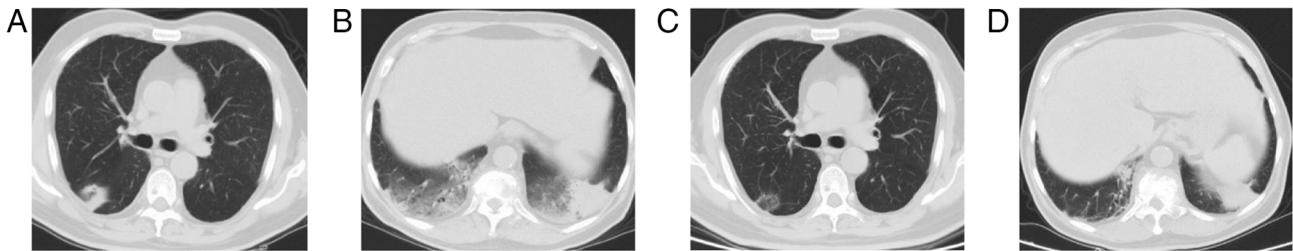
CT images of checkpoint inhibitor pneumonitis before and after corticosteroid therapy. (A) CT image at the level of the intermediate bronchus showing pneumonitis after three cycles of immunotherapy (October 2020). (B) CT image at the level of the bilateral lower lung showing pneumonitis after three cycles of immunotherapy (October 2020) (C) CT image at the level of the intermediate bronchus showing notable improvement of pneumonitis after administration of corticosteroids (November 2020). (D) CT image at the level of the bilateral lower lung showing notable improvement of pneumonitis after administration of corticosteroids (November 2020). CT, computed tomography.
